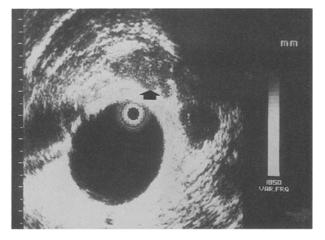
Patient 3. Endorectal ultrasound showing the tumor growing within the muscularis propria (arrow) and protruding forward into the submucosal and muscle layers. Expansion of the first hypoechoic layer with some degree of irregularity of the submucosal and muscle layers was found.
